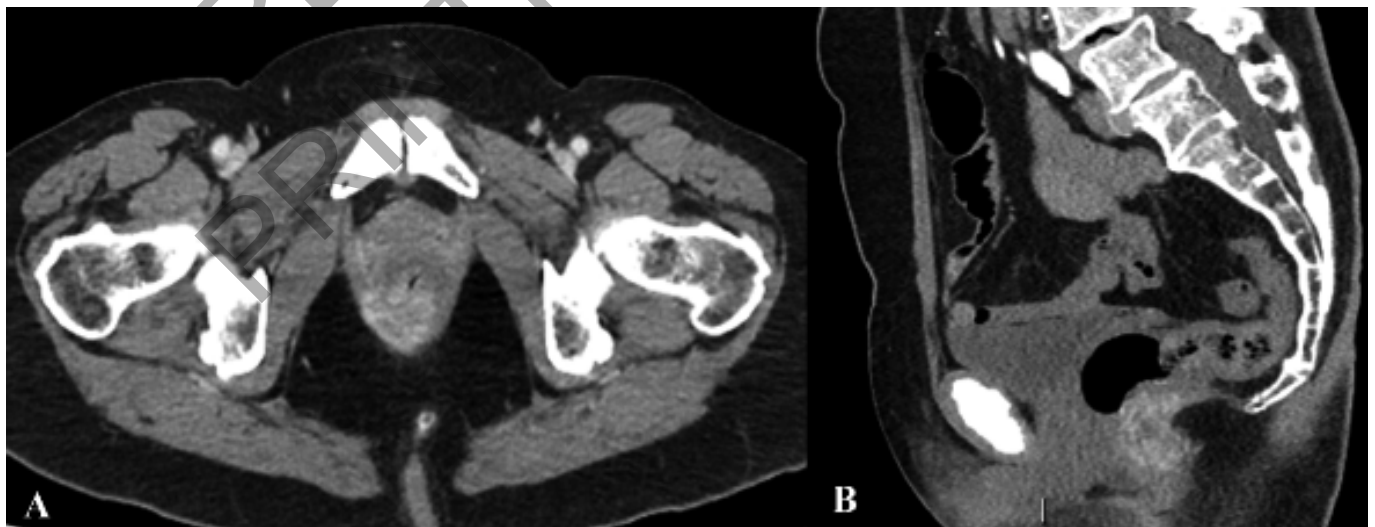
Axial CT venous phase (A), with sagittal reconstruction (B), demonstrate the hypervascular mass involving the posterior wall of the anal canal, with external sphincter infiltration on the right side, referable to the primary anal neoplasm.
